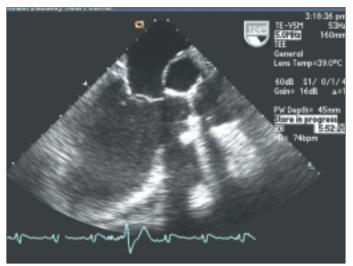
Transesophageal two-dimensional image at an angle of 124°, showing the pseudoaneurysm.
